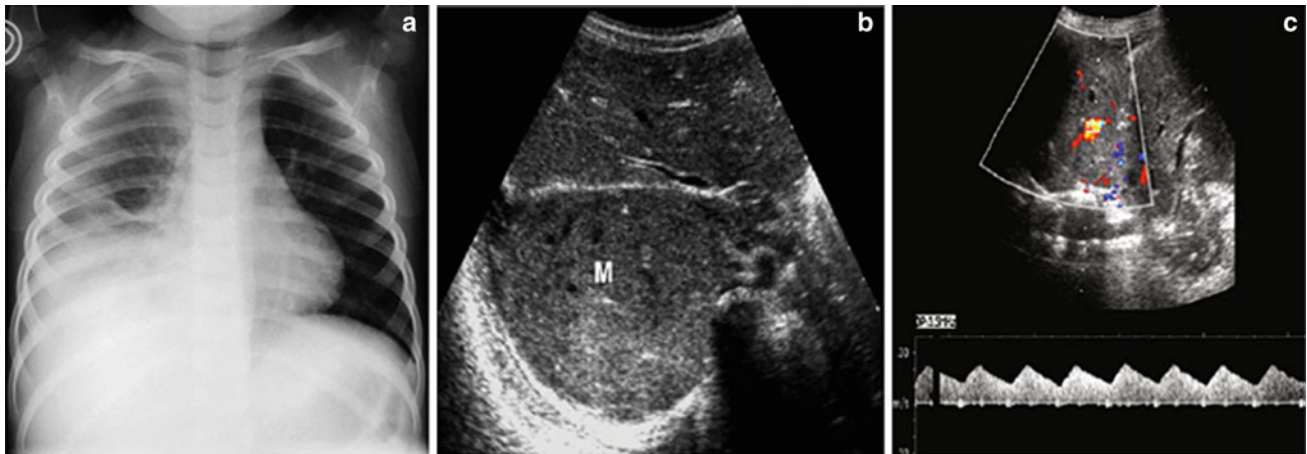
Numerous sonobronchograms not visualized on the chest plain film
